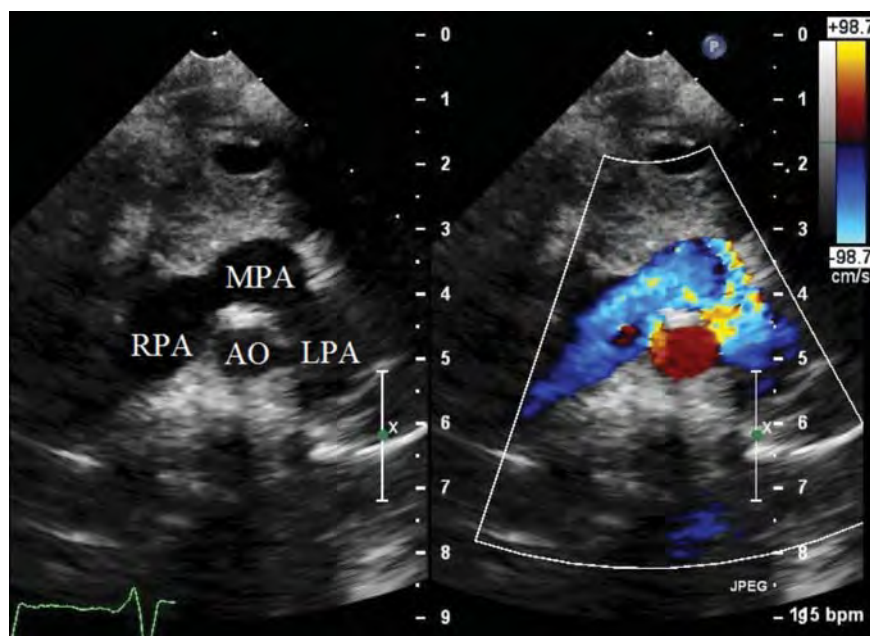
Suprasternal short-axis echocardiography view in color Doppler mode. Postoperative (double switch procedure) study showing the anatomy status post Lecomte maneuver. The main pulmonary artery has been brought forward and the branch pulmonary arteries now drape around the newly constructed ascending aorta. AO, aorta; LPA, left pulmonary artery; MPA, main pulmonary artery; RPA, right pulmonary artery.
